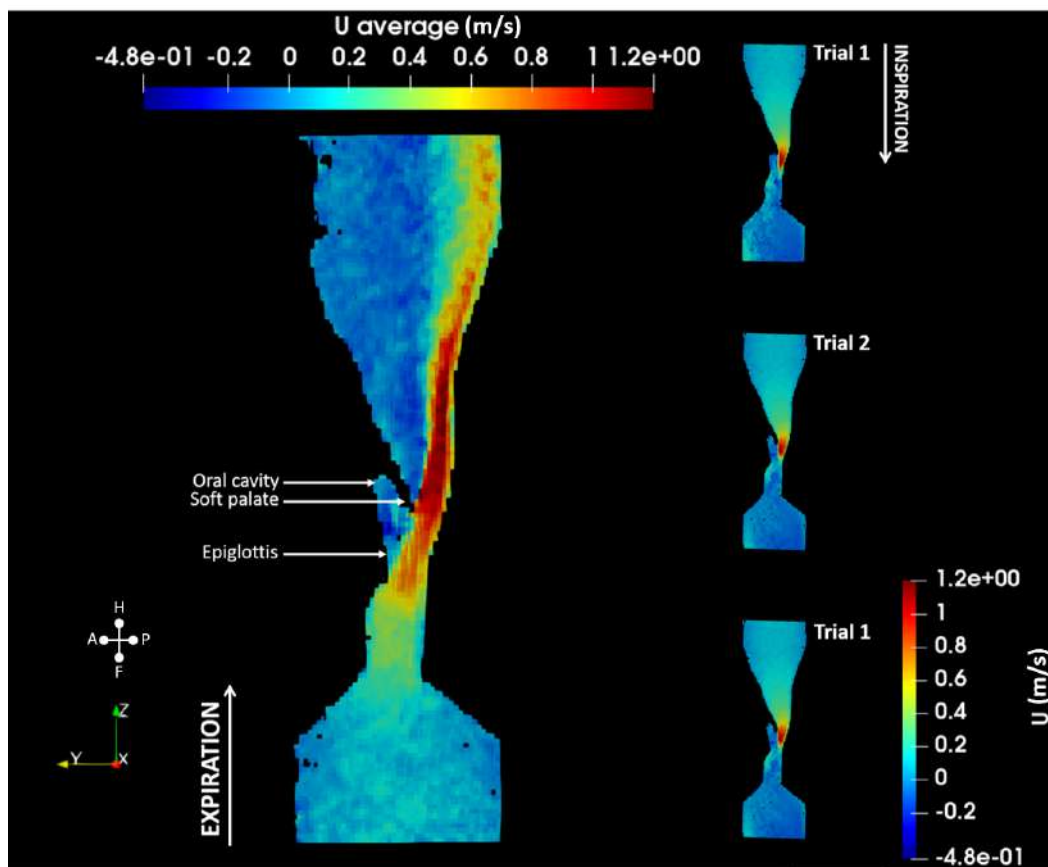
Sagittal slice of pharynx model during expiration and inspiration obtained from 2D PC-MRI.
